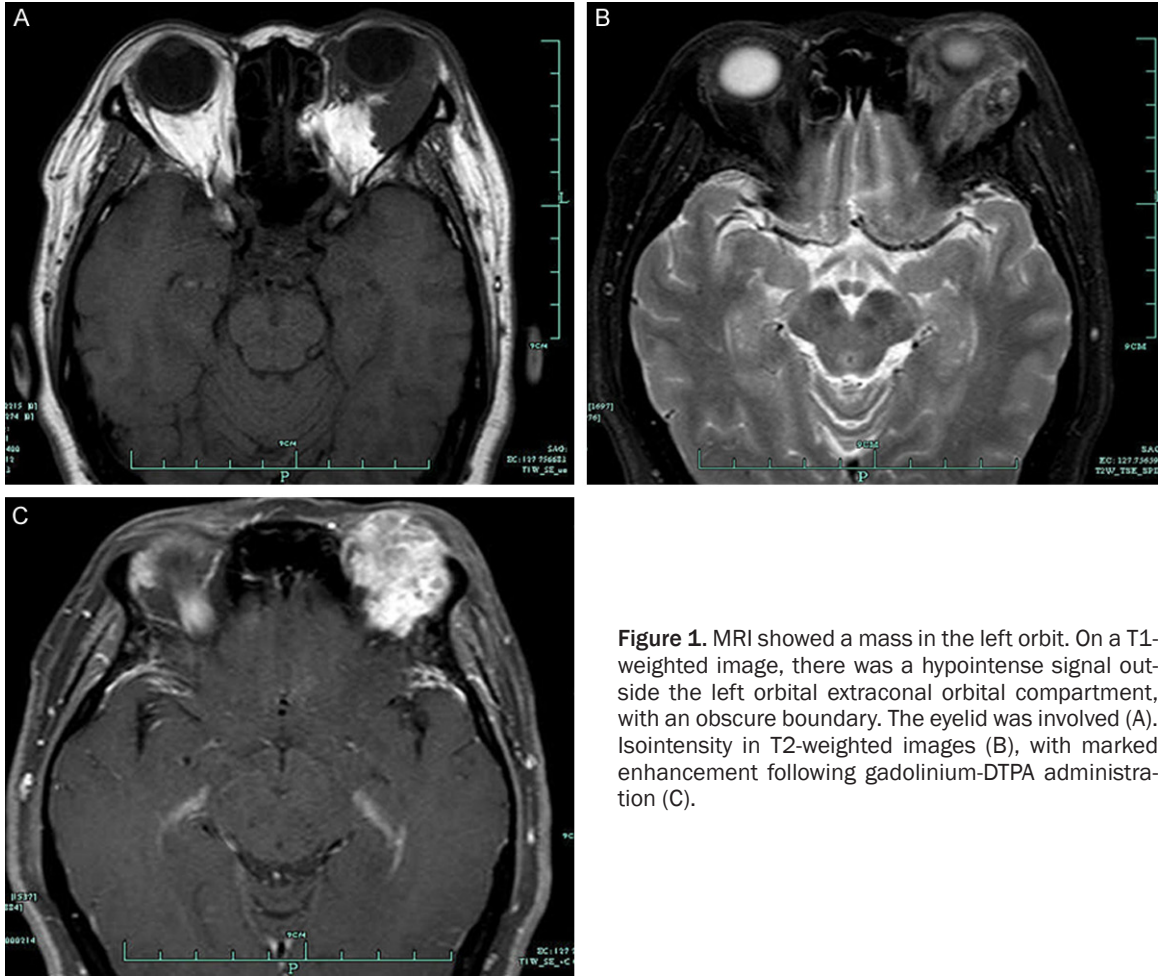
MRI showed a mass in the left orbit. On a T1-weighted image, there was a hypointense signal outside the left orbital extraconal orbital compartment, with an obscure boundary. The eyelid was involved (A). Isointensity in T2-weighted images (B), with marked enhancement following gadolinium-DTPA administration (C).
